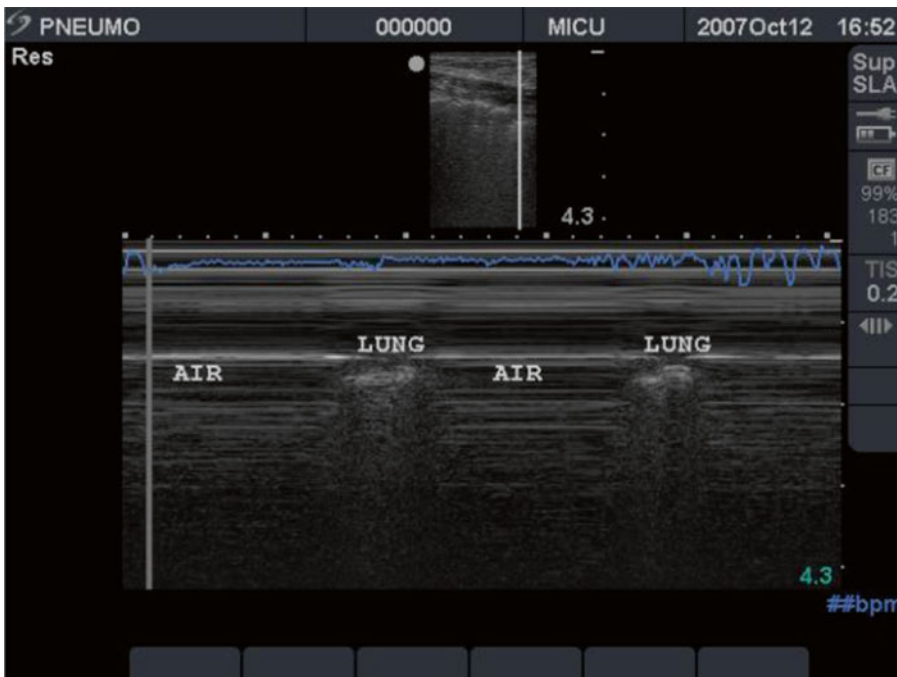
Ultrasound demonstrates several findings consistent with a pneumothorax (see text for details). Courtesy of www.Criticalecho.com with permission
